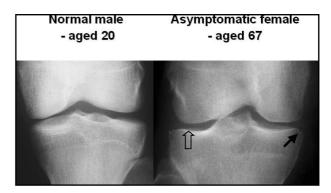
The contrast between the knee x-ray of a normal, asymptomatic 20 year old male (left) and an equally normal asymptomatic 67 year old woman (right) is shown. Whilst the lady has minor rim osteophytes (solid arrow) and slight joint space narrowing (open arrow), it would be overstating the case to diagnose this as OA.
